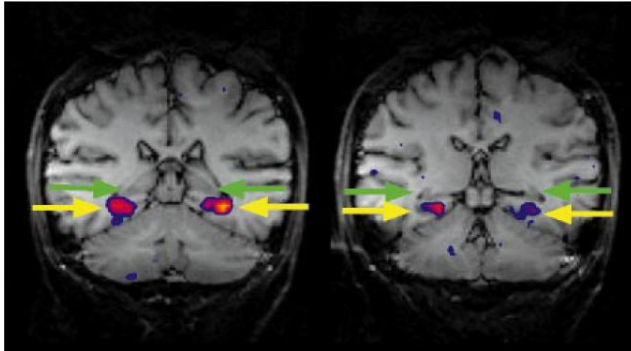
Two adjacent slices from a single subject demonstrating the anatomical location of the PPA. Functional data is overlaid on high-resolution T1-weighted anatomical images of the same slices. Right hemisphere appears on the left. Color-coded significance levels reflect the results of a Kolmogorov–Smirnov test comparing the MR signal intensity during viewing of intact scenes to signal intensity during viewing of intact objects and faces. Note that the PPA (yellow arrows) does not overlap with the posterior part of the hippocampus (green arrows). Posterior slice appears on the left. Talairach coordinates of PPA activation for this subject are $-6, 18, -39$ and $-6, -34, 30$.
